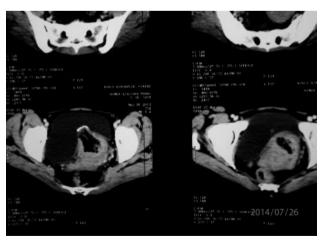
MRI before operation.
